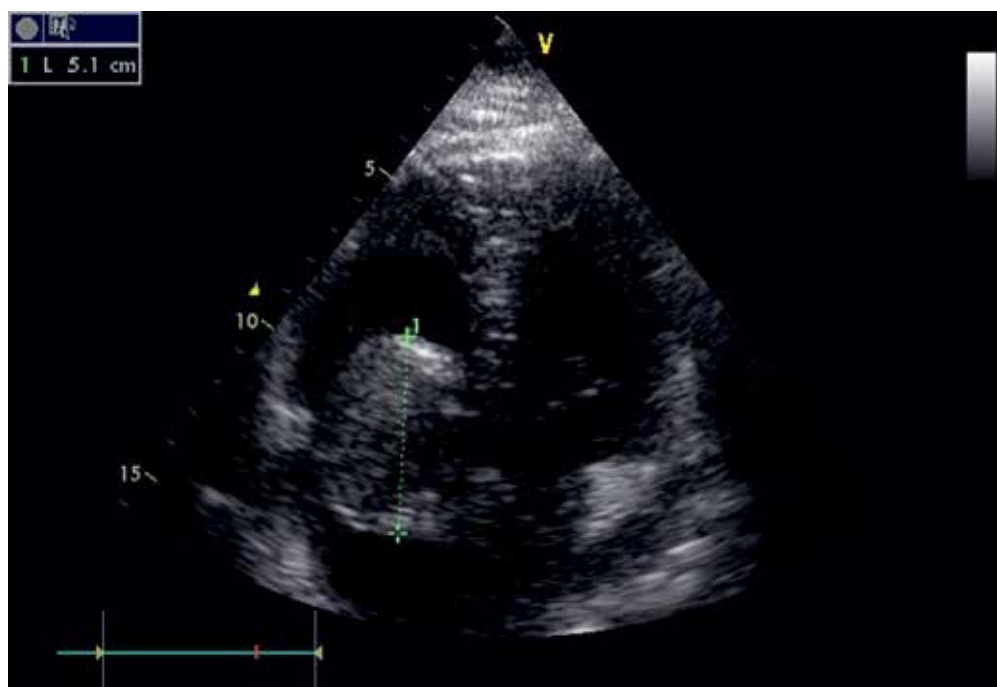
The echocardiographic 2D four-chamber apical projection, which showed the tumor of the right atrium 33 mm × 51 mm in size, pedunculated by interatrial septum, movable, and of diversified structure
